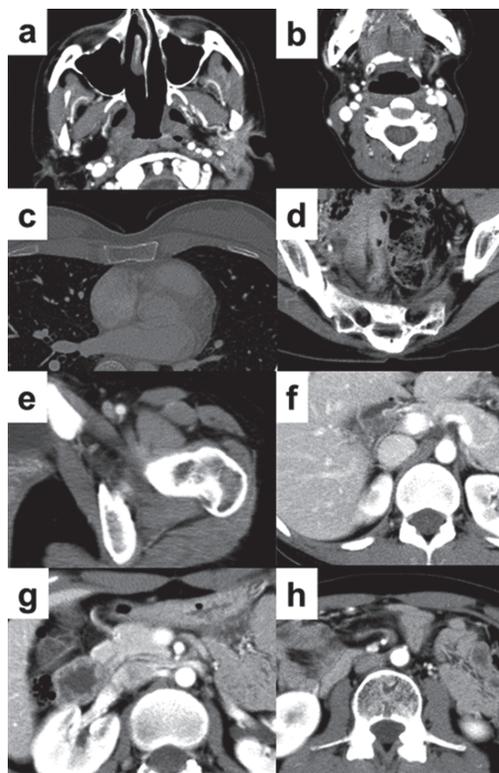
CT images at 10-year after the last radiotherapy
